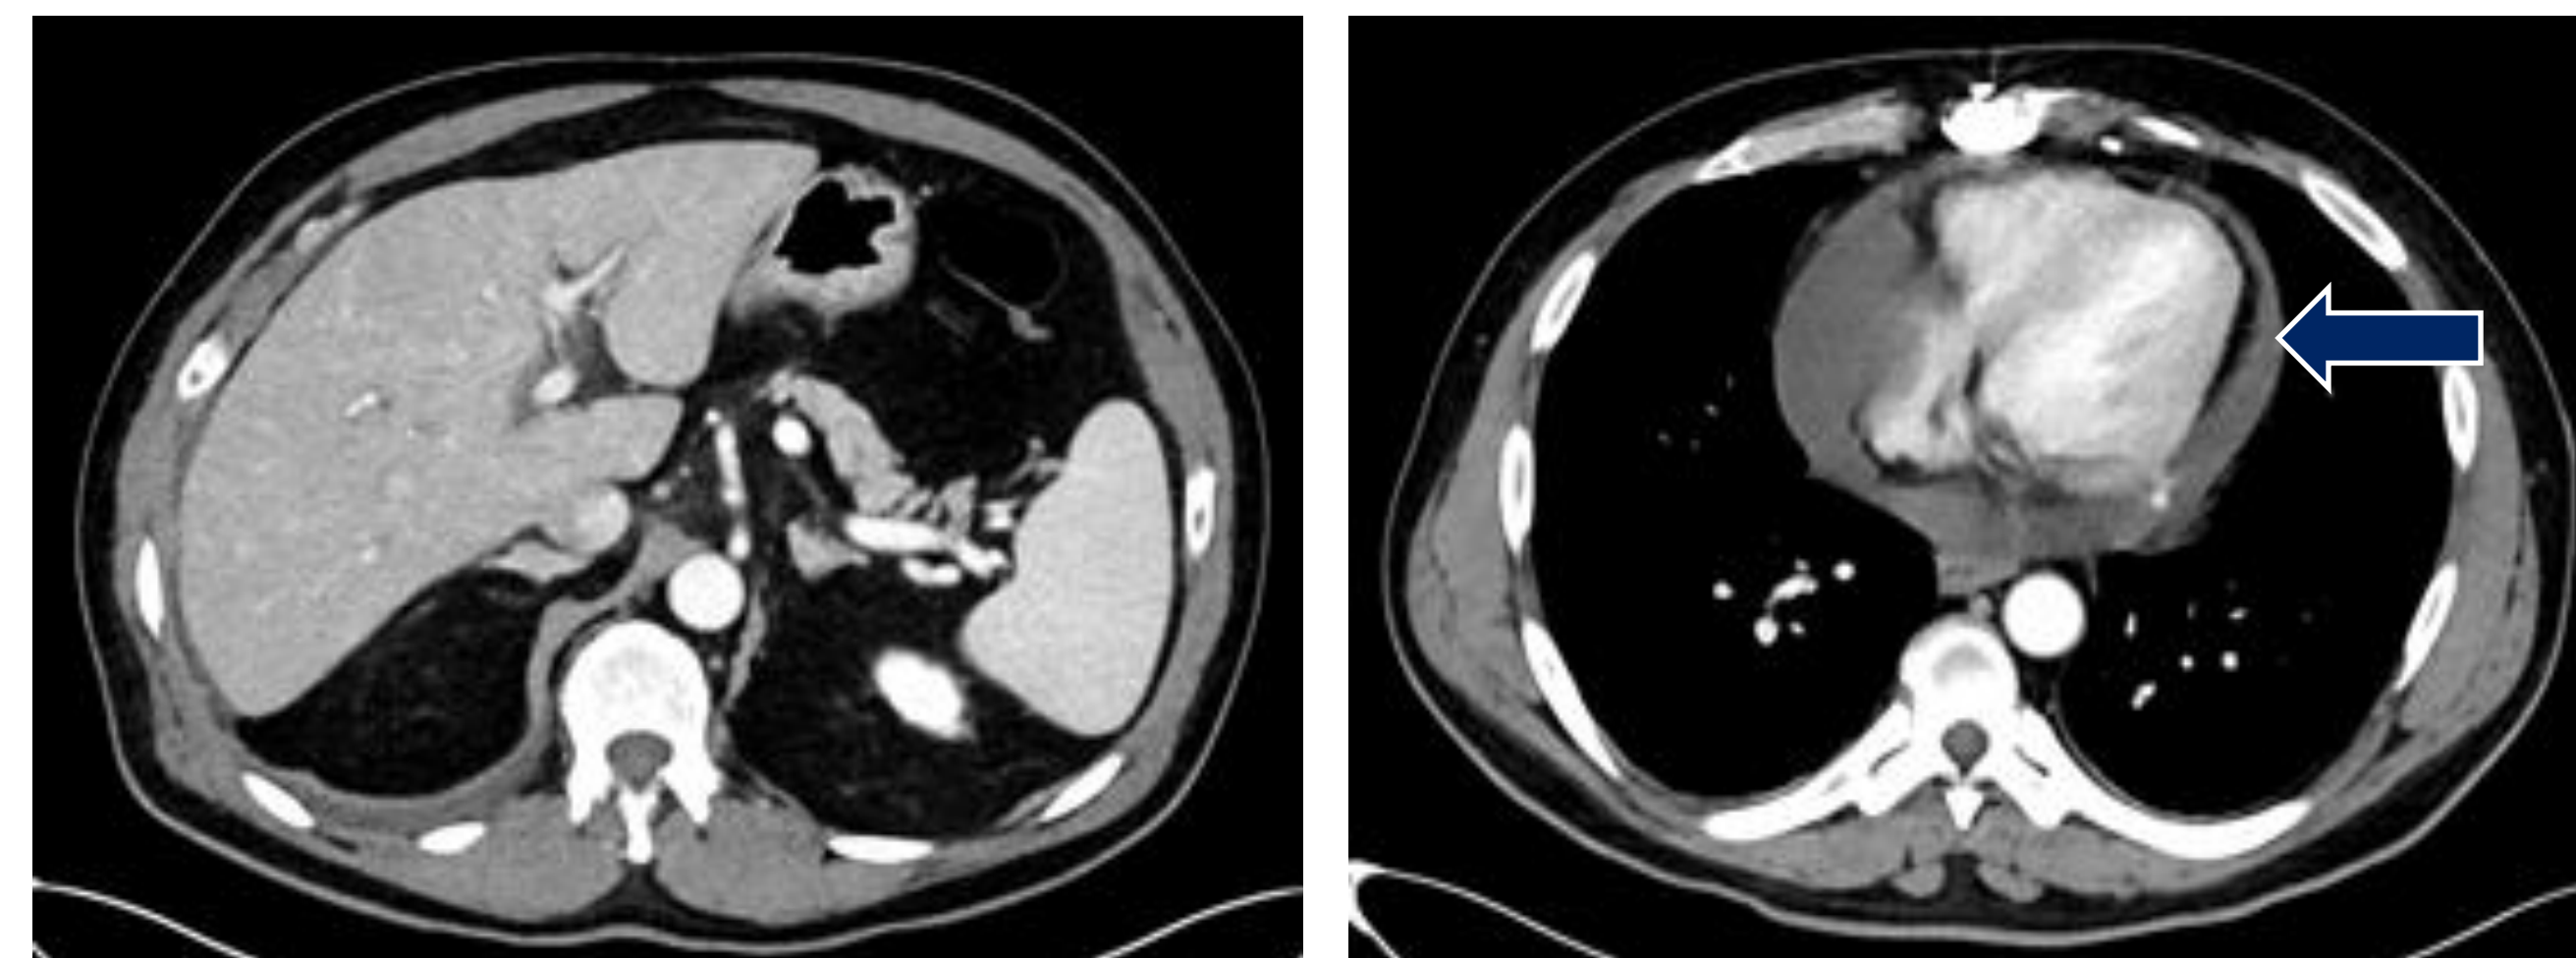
Computed Tomography with Contrast.
